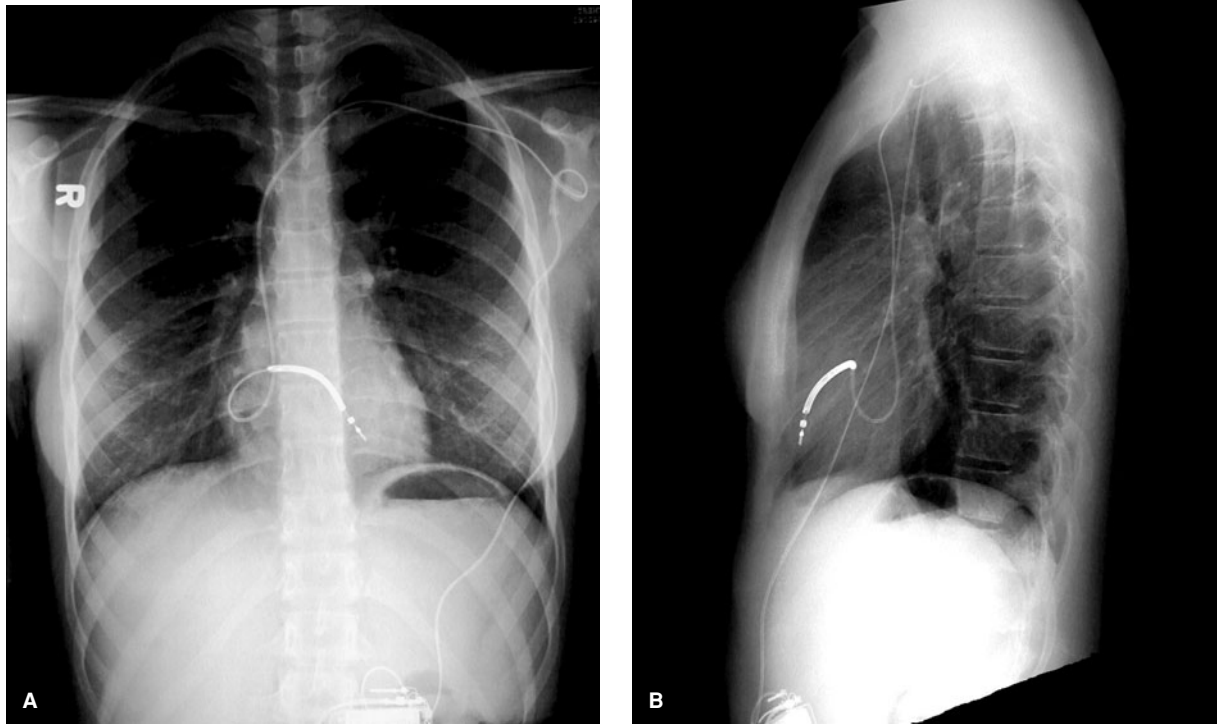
(A) ICD implant in 13-year-old female with long QT syndrome. X-rays reveal an intracardiac loop to allow for growth and a strain relief loop in the left shoulder. A single-coil, screw-in lead was used to permit an intracardiac loop, but improved leads now allow twin-coil leads to be used. This implant utilized cosmetic positioning of the generator in the posterior rectus sheath. (B) Lateral x-ray of same patient.
